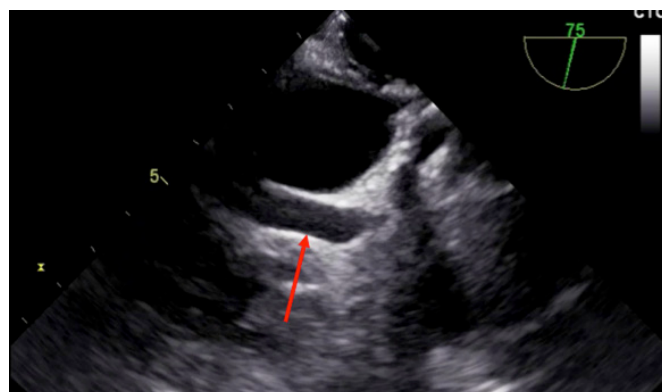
Echocardiography showing enlarged right coronary artery (red arrow).
